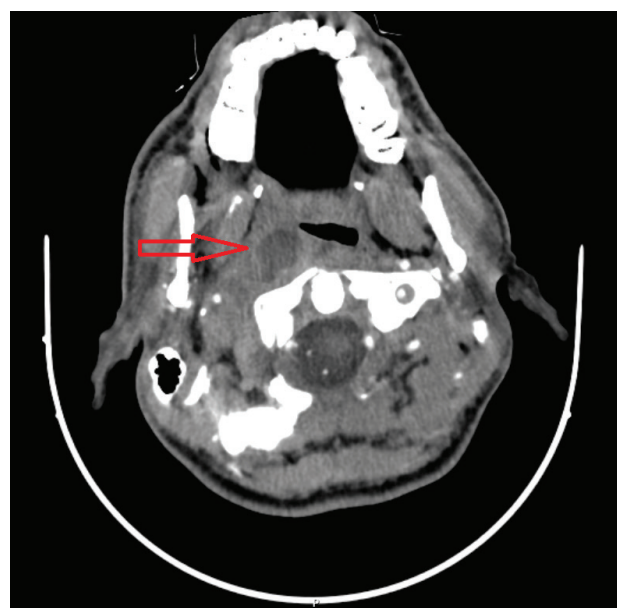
Contrast-enhanced neck computed tomography demonstrating a right-sided peritonsillar/parapharyngeal abscess without evidence of internal jugular vein thrombosis.
